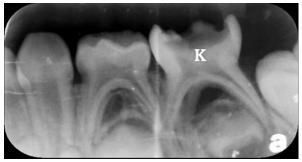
Radiographic image of the primary mandibular left second molar.
